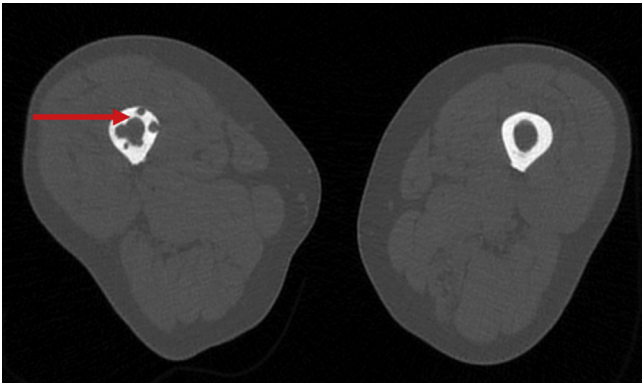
CT scan of right and left thighs showing decreased density lesions (red arrow) within the cortex of the right femur.
